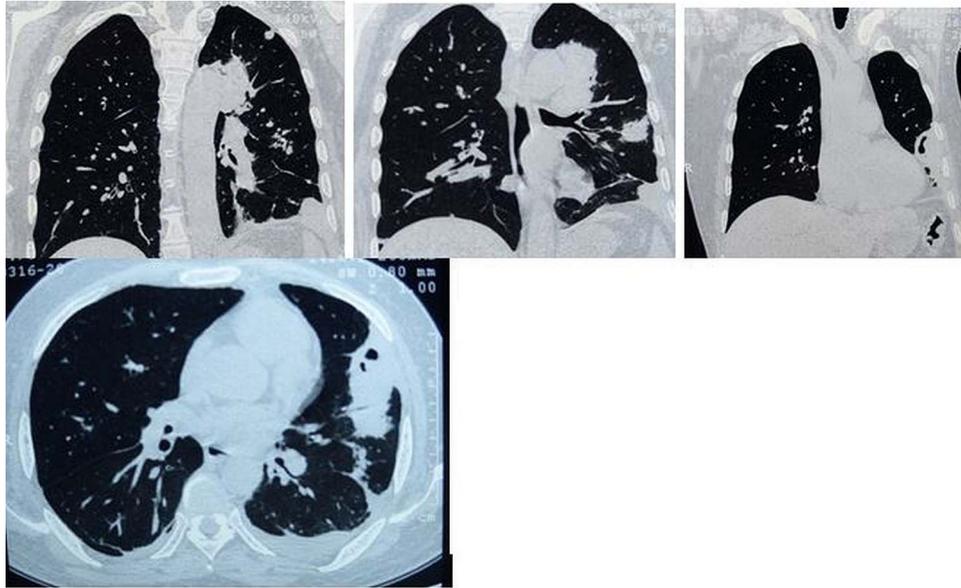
CT of the chest showing consolidation with cavitation in the left lingual and left upper lobe, along with small nodules in the right lung parenchyma.
